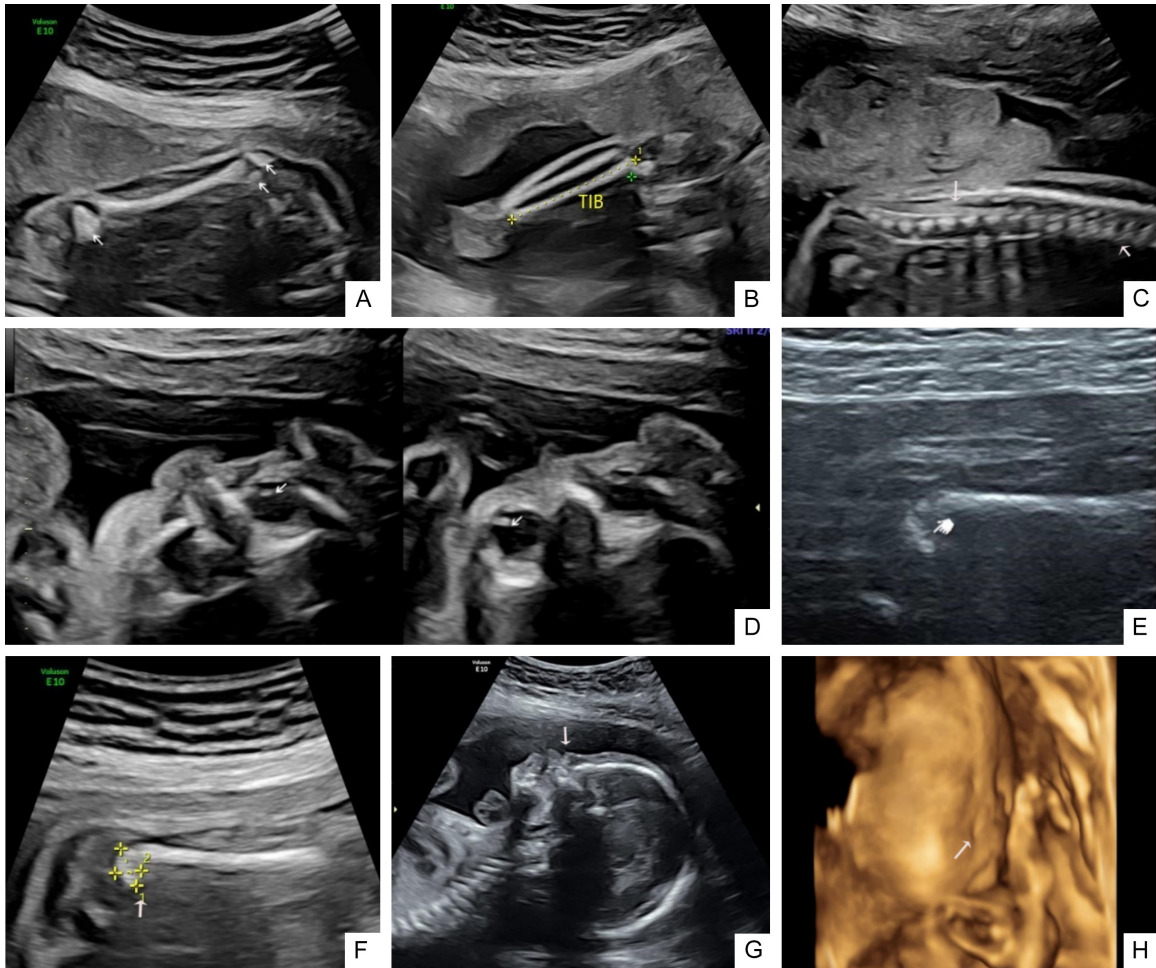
Ultrasound features in three fetuses. A-D. Fetus 1(24+6wg*). E, F. Fetus 4(24+6wg*). G, H. Fetus 5(24+6wg*). A, B. Epiphyseal stippling, thick metaphysis, shortening of the tibial and the femur; C. Small spine of the T5-11 vertebrae, coronal fissures in the T12, L1, and L2 vertebrae, and lowering conus medullaris; D. Enhancing bilateral peripheral echoes of the crystalline lens, showing “bilateral sign”; E. Epiphyseal stippling of the femur; F. Thick metaphysis of the femur; G. Flat nose bridge, collapsed nasal wings, nose tip lower than upper lip and short nasal bone; H. Three dimensional imaging collapsed nose deformity. Abbreviations: wg*, weeks of gestation.
